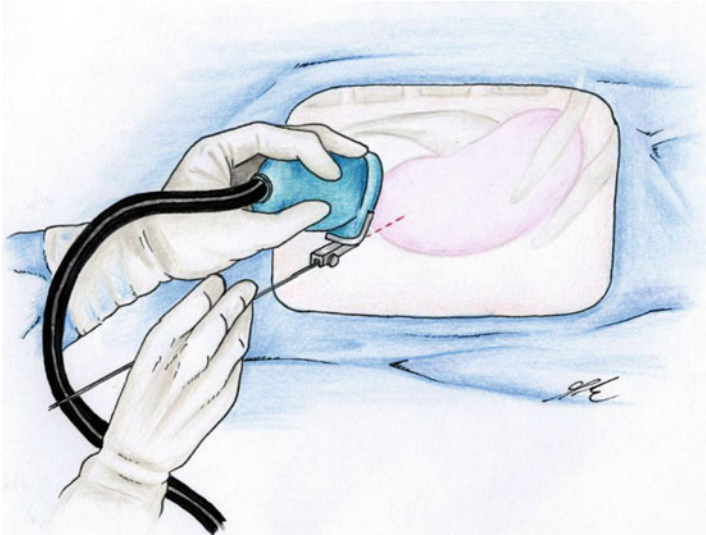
Ultrasound-guided puncture of the lower renal pole using a probe with needle guide adapter
